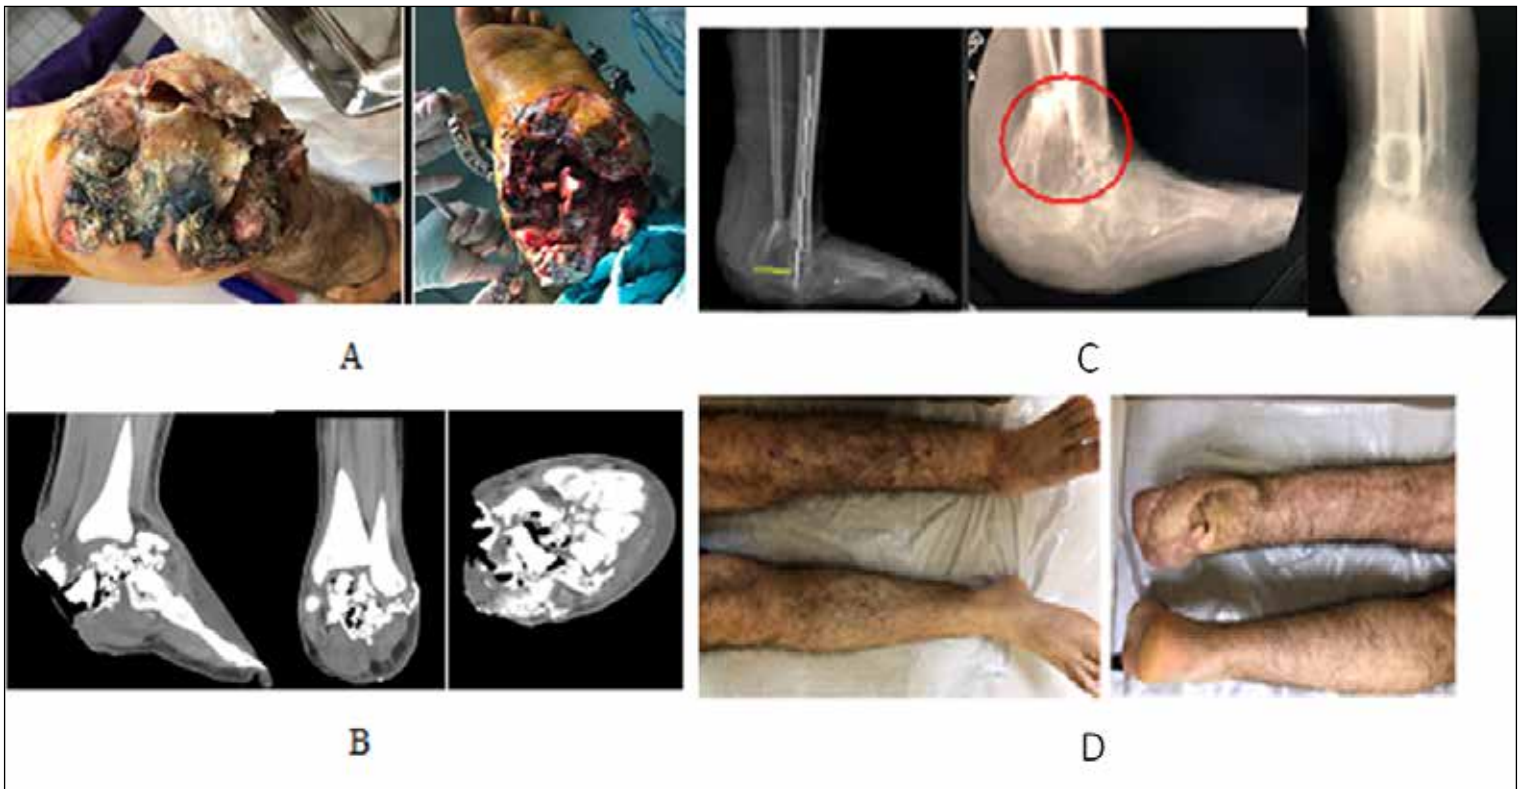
Patient M, 21 years old. A. Mine blast injury, soft tissue defects of right foot, extensive necrotic wound in the area of the left heel, comminuted fractures of the left calcaneus, talus, navicularis and cuboid bones. Admitted one month after the injury. Appearance of the wound at admission. B. CT scan of the foot at admission: comminuted fractures of the calcaneus, talus, navicularis and cuboid bones are visible. C. X-rays of the foot and ankle joint after completing treatment - 6 reconstructive surgeries (including 2 limb-lengthening by 4 cm each time). D. Clinical aspect at the end of treatments. [courtesy Prof. C. Alizadeh]
